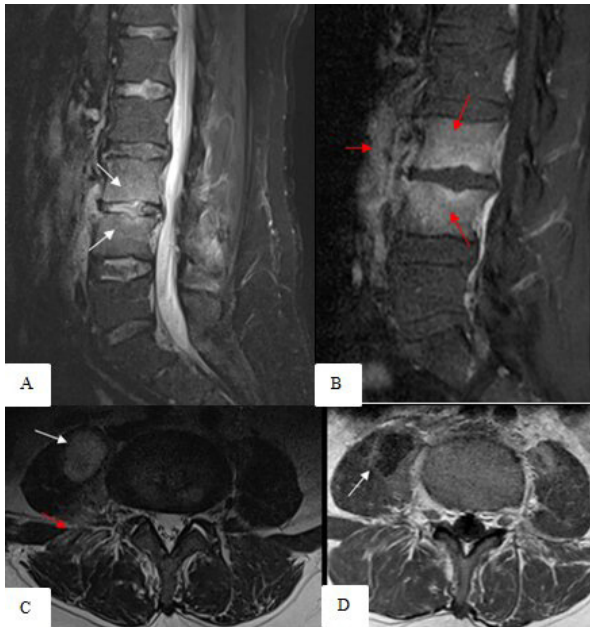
Lumbar MRI demonstrating abnormally increased signal intensity involving L3-L4 vertebral bodies on sagittal STIR image (A, white arrows) and the contrast enhancement in both the involved vertebral bodies and also in the inflammatory prevertebral soft tissue on sagittal postcontrast T1w image (B, red arrows). Abnormal signal intensity involving the right prevertebral soft tissue (C, red arrow) and the encapsulated hyperintense collection in the right psoas muscle (C, white arrow) are demonstrated on axial T2w image. The enhancing wall with central necrotic cavity on axial postcontrast T1w images (D, white arrow) is shown
